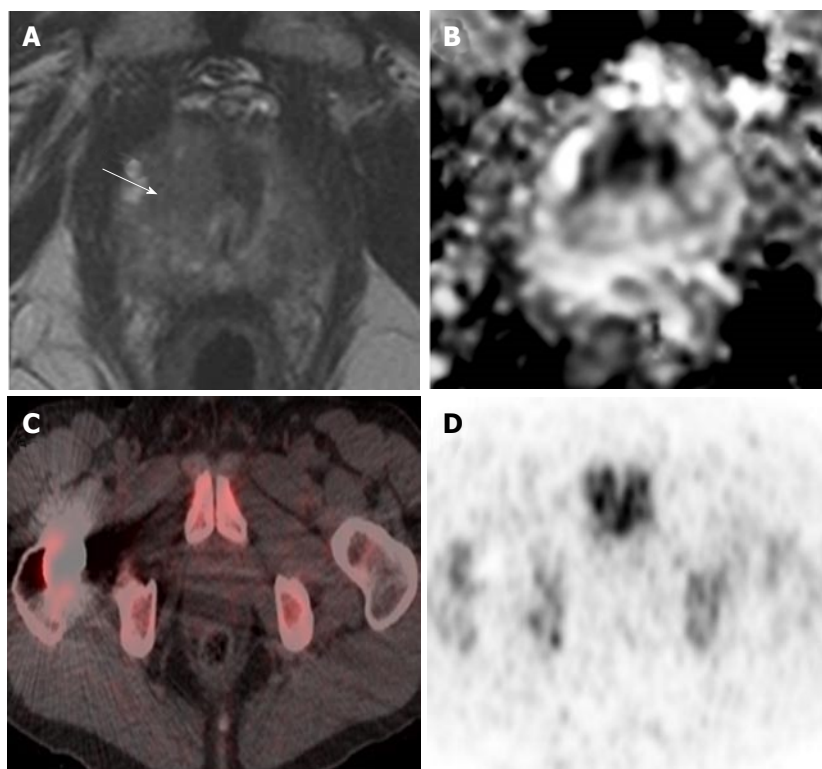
High-grade prostate cancer showing no increased uptake on positron emission tomography/computed tomography in a 73-year-old man. A, B: Prostate MRI performed for raised PSA (19 ng/mL) showed a high probability lesion in the right apex transition zone (arrow in A) with matching restricted diffusion on the ADC map (B). Subsequent targeted transperineal biopsy confirmed Gleason 4 + 5 disease in 40% of cores; C, D: PET/CT performed after a two-month interval and no intervening treatment showed no focal uptake in this region shown as both fused PET/CT imaging (C) and PET alone (D). PET/CT: Positron emission tomography/computed tomography; MRI: Magnetic resonance imaging; ADC: Apparent diffusion co-efficient; PSA: Prostate specific antigen.
